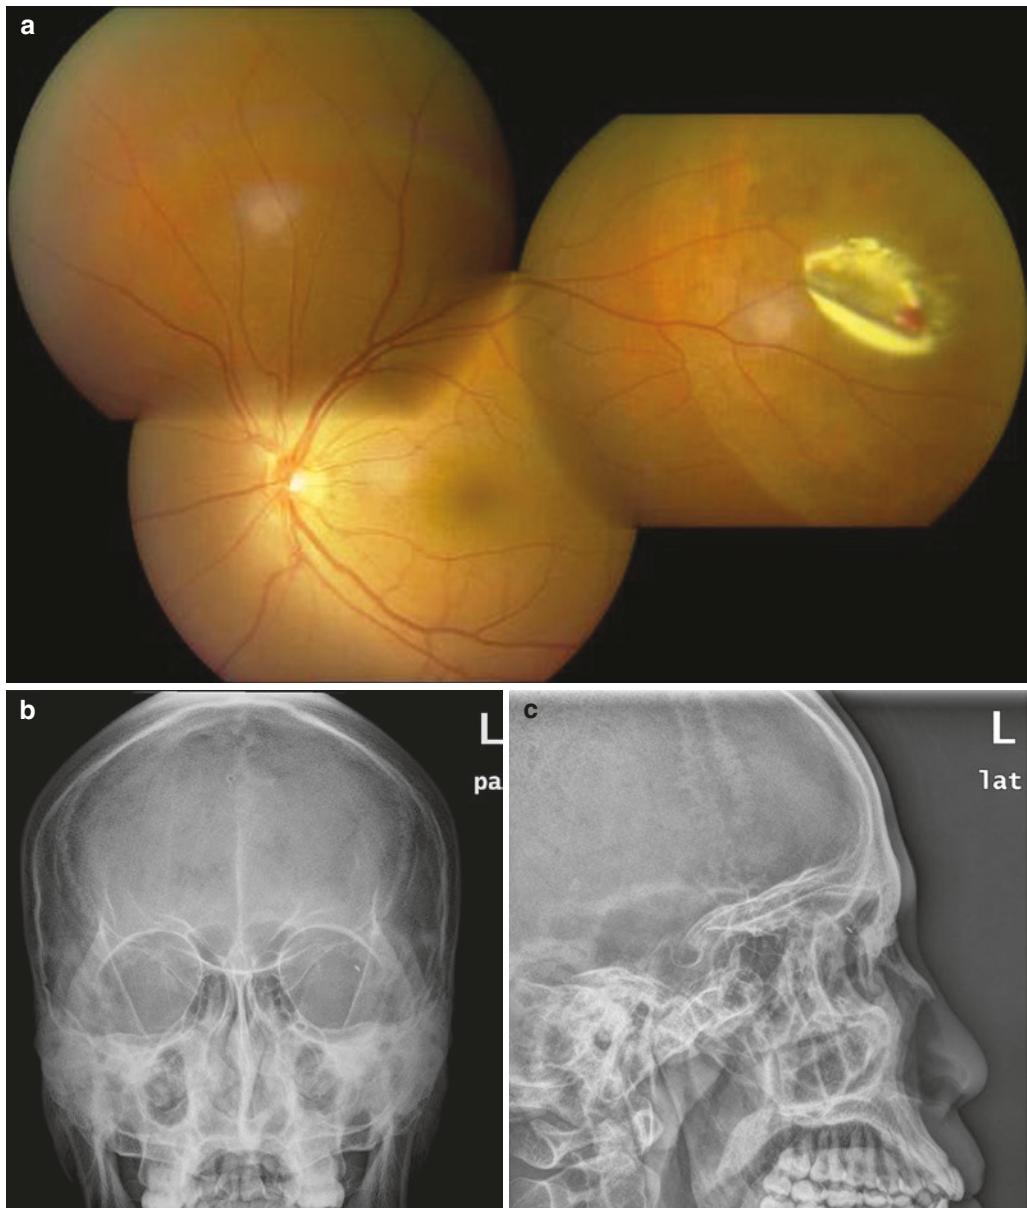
(a) Color fundus photograph and (b, c) X-ray of a patient with intraocular foreign body
